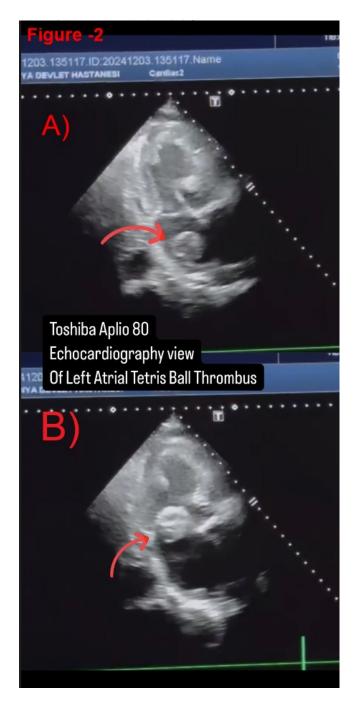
A) Echocardiographic image of moving tetrix ball thrombus in the left atrium with Toshiba Aplio 80 echocardiography device. B) Toshiba Aplio 80 echocardiogram showing a moving tetrix ball thrombus in the left atrium trying to pass through the mitral valve
